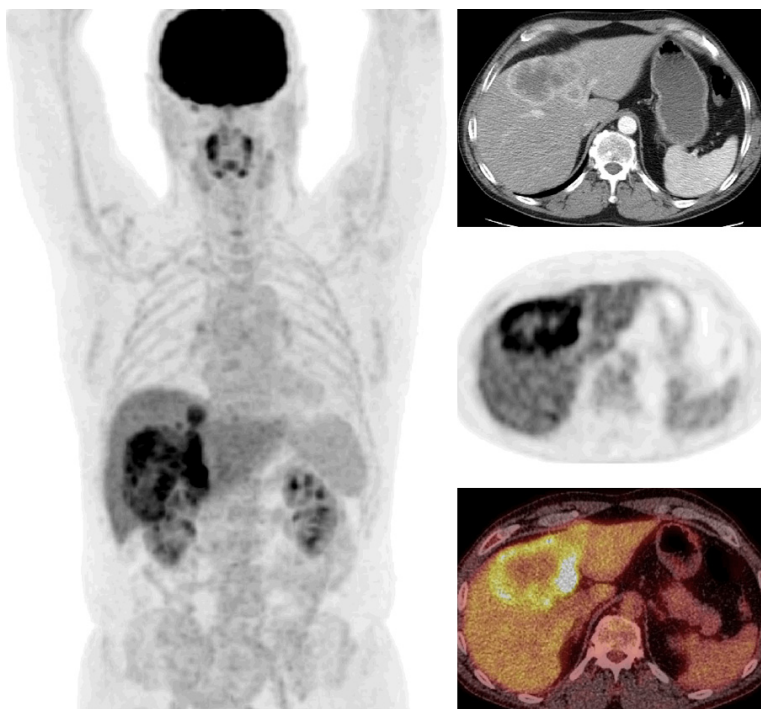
FDG PET/CT images of a case with mass forming cholangiocarcinoma (whole body MIP, selected transaxial contrast enhanced CT, PET, and PET/CT fusion images of the liver). CT shows peripheral enhancement and PET shows central photopenia with peripheral hypermetabolic activity in a large liver mass (tumor SUVmax: 13.5, liver SUVmean: 2.8). An additional small focus of tumor is also seen superior to the primary tumor on whole body MIP image.
